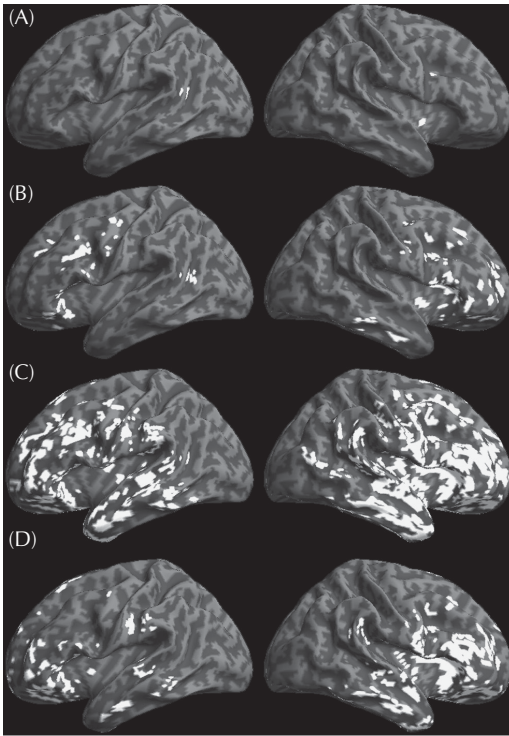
Grey matter density derived from T1-weighted magnetic resonance imaging. (A) Regions of atrophy in ALS with normal cognition relative to elderly control subjects. (B) Regions of atrophy in ALS with mild cognitive impairment relative to elderly control subjects. (C) Regions of atrophy in ALS-FTD relative to elderly control subjects. (D) Regions of atrophy in ALS-FTD relative to ALS with normal cognition. (Courtesy of Penn Frontotemporal Degeneration Center.)
